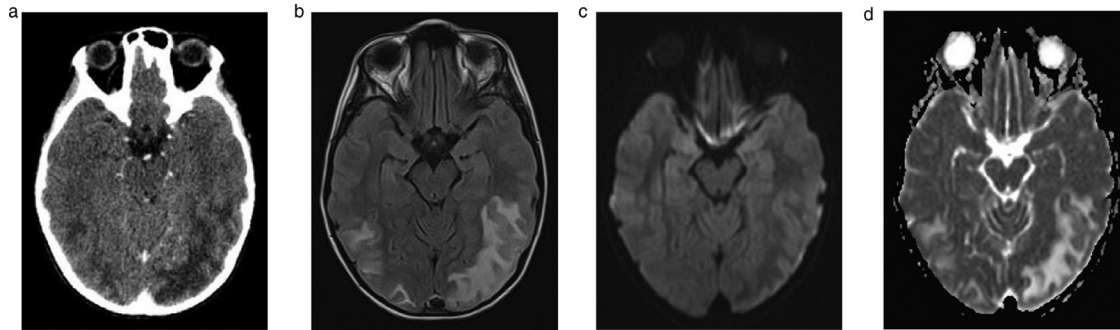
Brain CT scan (A) showing areas of ill-defined hypoattenuation involving predominantly the subcortical white matter in both parietal and occipital lobes, with no mass effect, contrast enhancement, or cranial hemorrhage. On brain MRI, the described areas on CT scan are generating high signal on T2 FLAIR images (B), low signal on DWI with high apparent diffusion coefficient (ADC) (C, D).
